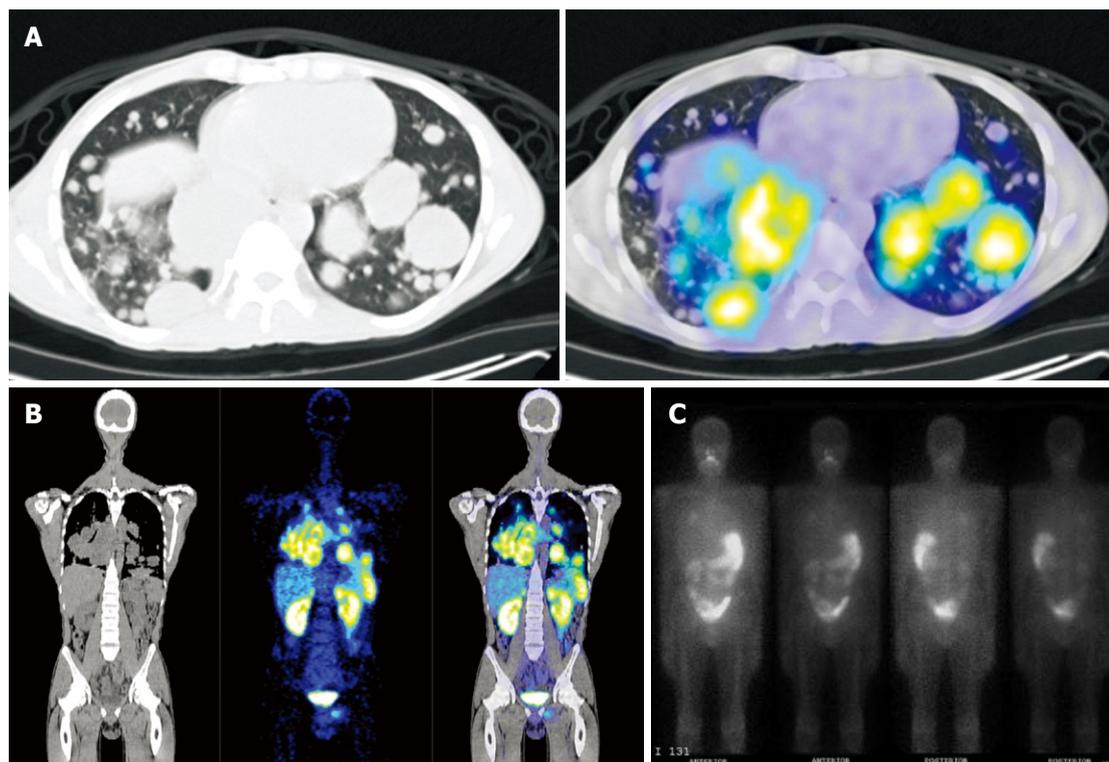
Metastatic non-iodine avid Hurthle cell thyroid carcinoma. A: Axial CT and PET/CT section of the thorax shows multiple pulmonary masses demonstrating avid tracer uptake; B: Coronal CT, PET and PET/CT images show somatostatin receptor rich pulmonary and mediastinal masses, and another discrete lesion projected over the left pelvis; C: I131 Whole body planar scan of the same patient shows only faint iodine uptake projected over the right upper lobe.
